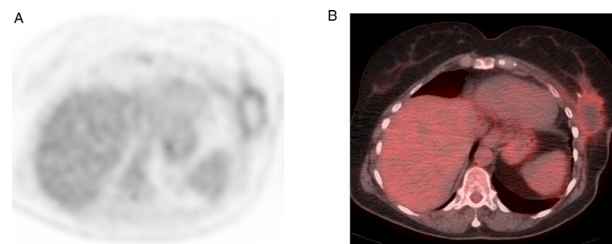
75-year-old female with invasive lobular carcinoma of the left breast. The patient underwent a left partial mastectomy and sentinel lymph node dissection. Postoperative axial PET and fused PET-CT images (A and B) showed a peripherally hypermetabolic mass in the left breast with central photopenia. Findings were consistent with a postoperative seroma.
